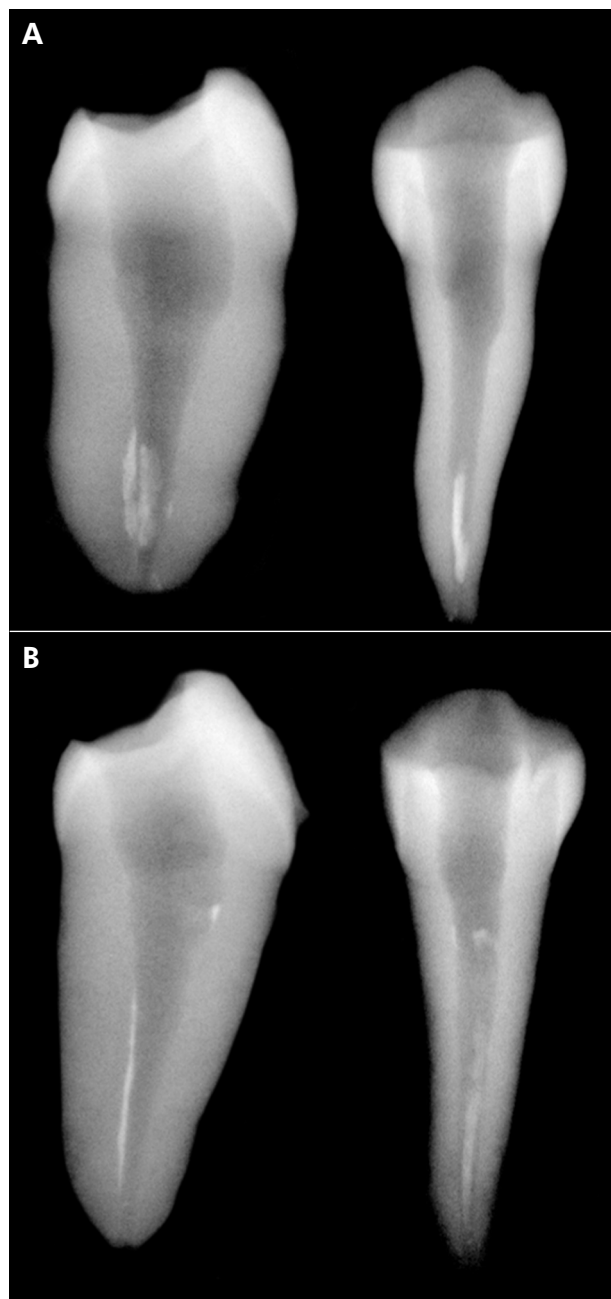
Representative radiographs of (A) PTRS and (B) WS in mesiodistal and buccolingual directions, showing filling remnants.
